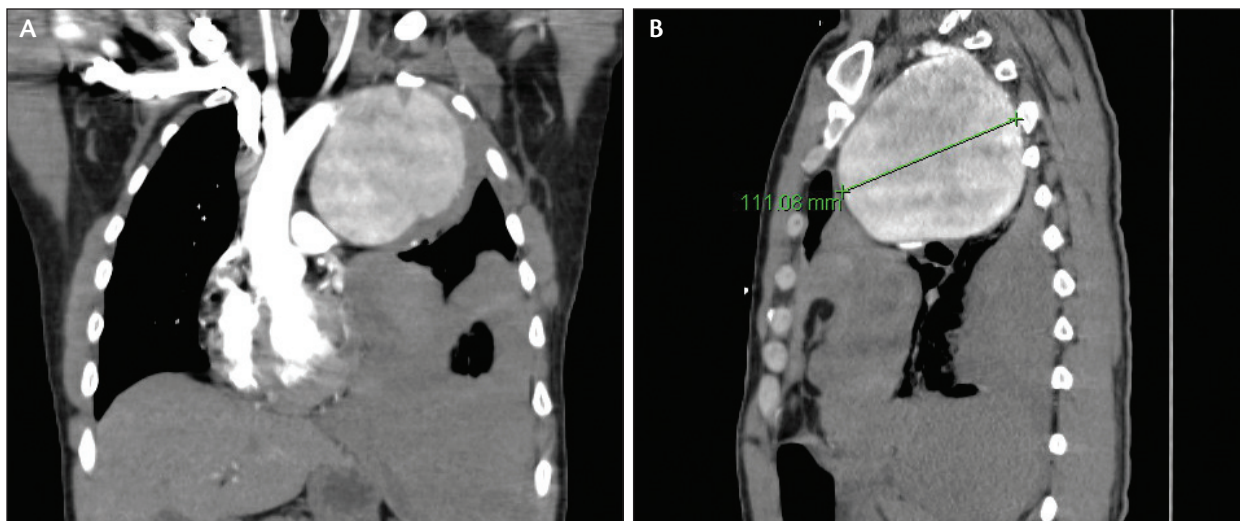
Coronal (A) and sagittal (B) CTA of a 47-year-old man with a history of open aortic coarctation repair who presented with an 11-cm ruptured descending thoracic aortic aneurysm.
